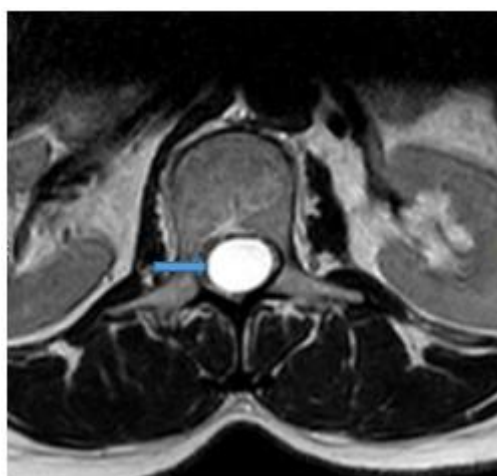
Axial plane of MRI showing intracanalicular intramedullary cystic in a high signal intensity on T2-weighted images
